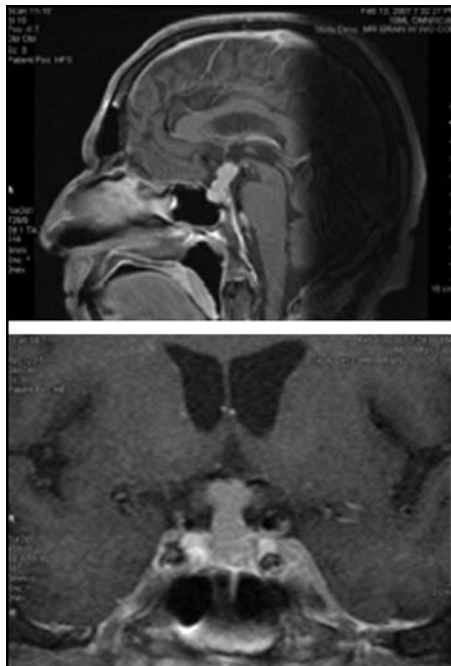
Pituitary-protocol brain MRI performed after patient developed double vision. Both sagittal (upper panel) and coronal (lower panel) images demonstrate thickening of the pituitary stalk with mass effect on the optic apparatus.
